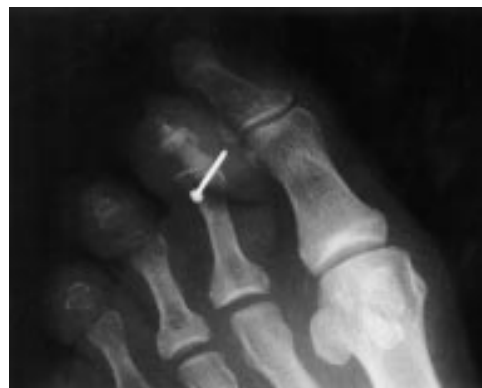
Radiograph showing the presence of a nail in the soft tissues.
